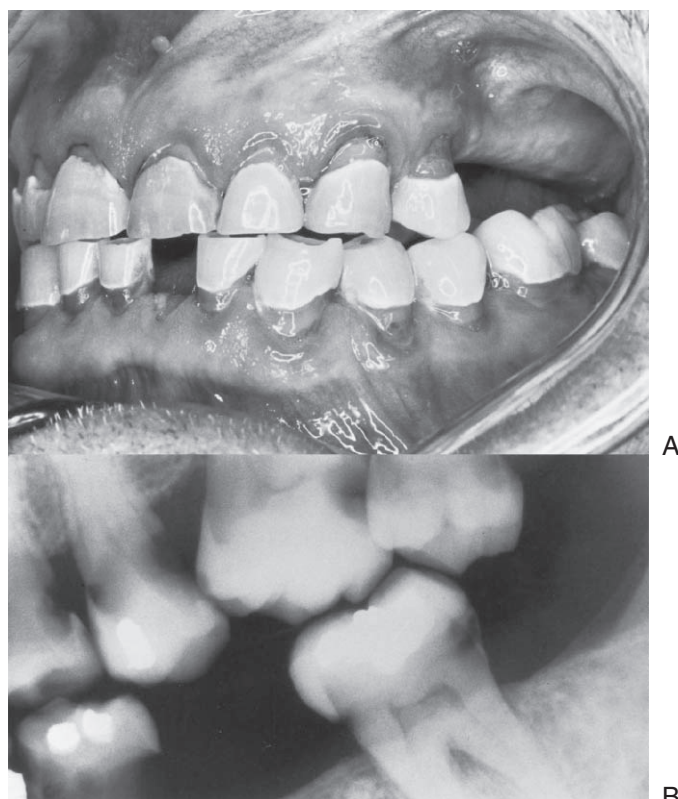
A, Typical clinical appearance of radiation caries of cervical and incisal surfaces. B, Typical radiographic appearance of radiation caries. Note the erosion around the cervical portion of the teeth. (From Peterson LJ, Ellis E, Hupp JR and others, ed: Contemporary oral and maxillofacial surgery, ed 4, St Louis, 2003, Mosby.)
